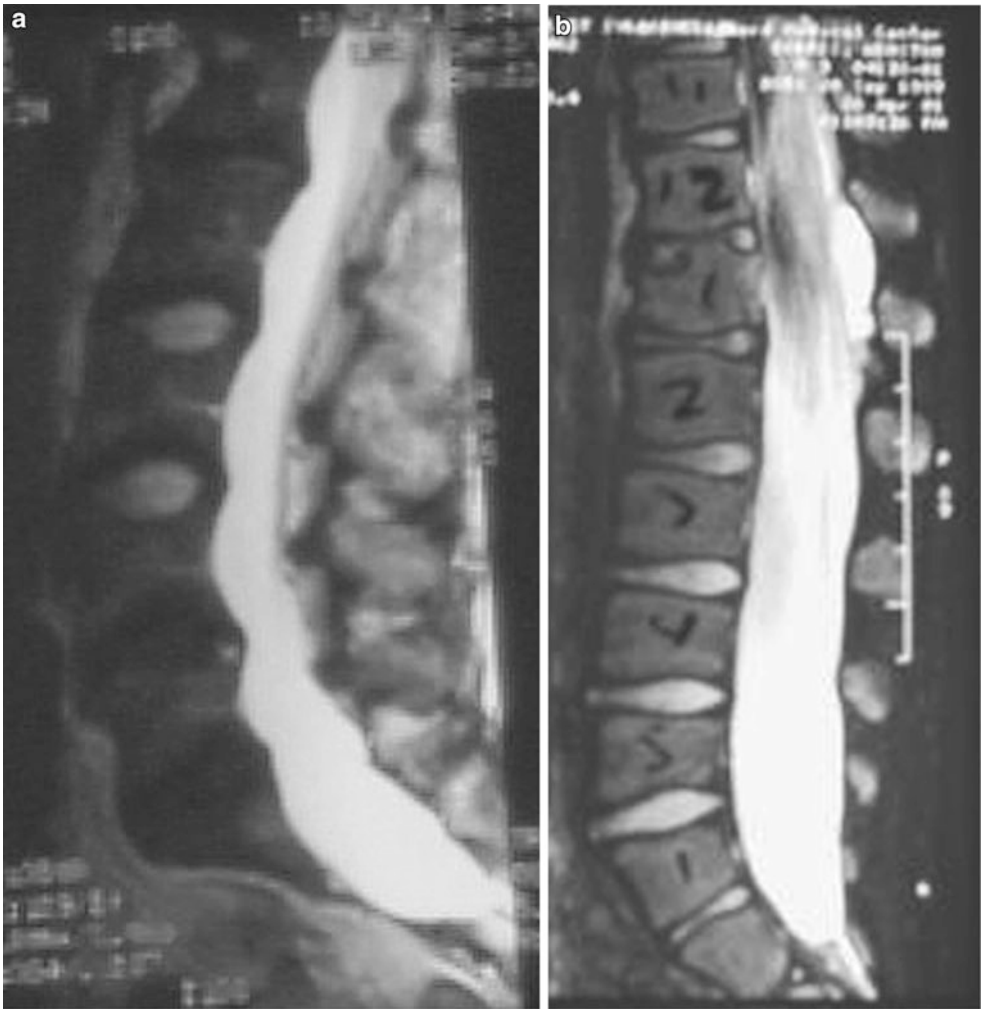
(a, b) MRI of the lumbosacral spine in two patients showing dural ectasia
